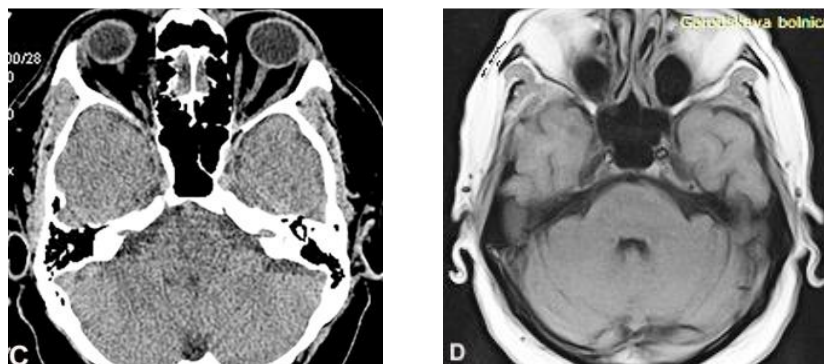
The same patient S., 42 years old, male, AD (TDR-1): CT and MRI of the brain before and after transcatheter intracerebral laser PBMT.
